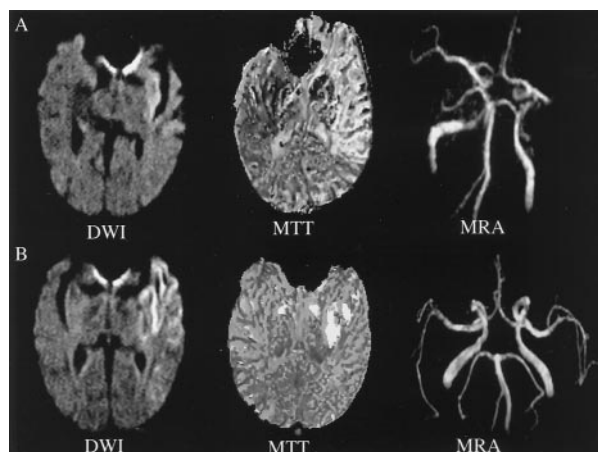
Case example of 73-year-old man with acute onset of left hemispheric syndrome (NIHSS score 21). A, MRI shows hyperintensity in the left insular cortex on DWI and a large area of prolonged mean transit time (MTT) on PWI in the distribution of the left MCA. MRA shows a left M₁ occlusion. He was treated with 0.9 mg/kg IV tPA 2 hours and 30 minutes after symptom onset. B, On MRI obtained 24 hours after symptom onset, DWI shows a small growth of the initial lesion and that the area of prolonged MTT has almost normalized and there is reperfusion in the M₁ segment on MRA with visualization of both M₂s. His NIHSS score was 6 at 3 days and 2 at 1 month.
